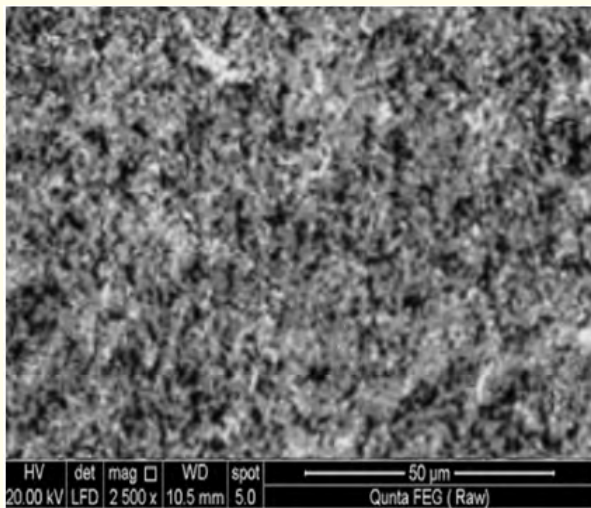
SEM of CT silica-coated zirconia surface.
